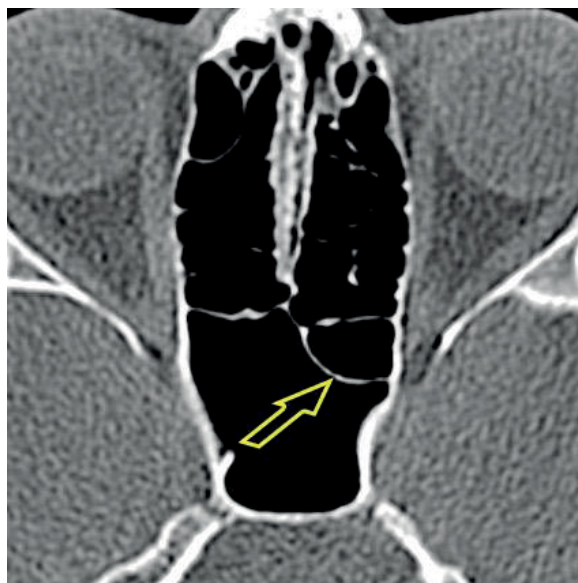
A CT scan of the paranasal sinuses, transverse plane. The dominant right sphenoid sinus. The course of the main septum shifts to the left and co-forms the posterior wall of the left sphenoid sinus (non-dominant).
